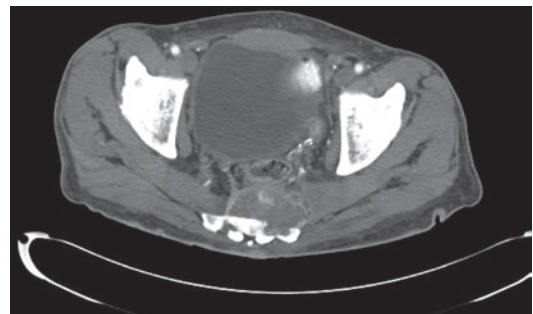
CT scan of the pelvis demonstrating posterior rectal cancer recurrence involving the sacrum.
